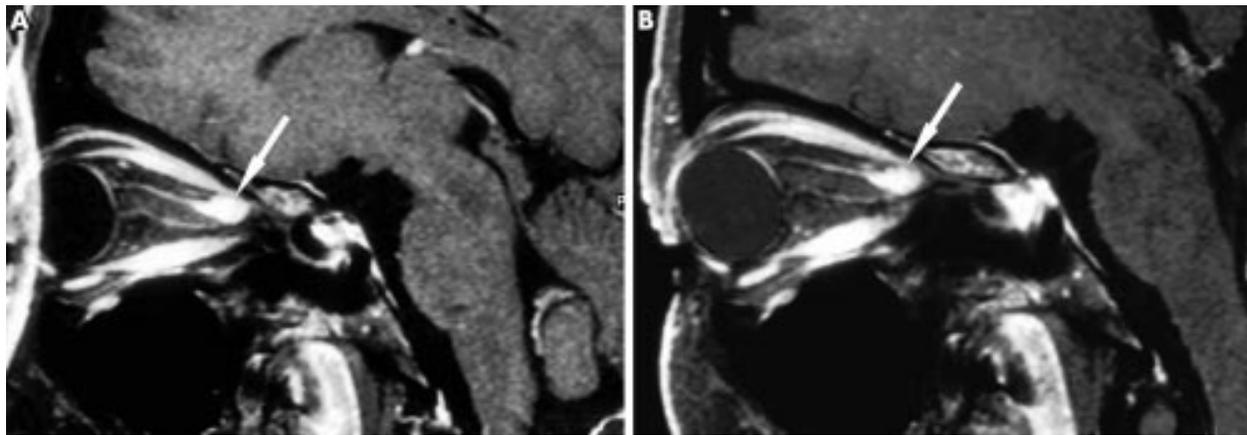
Sagittal T1 weighted magnetic resonance imaging, angulated along the course of the right optic nerve (time of repetition 500 ms, time of echo 16 ms, slice thickness 4 mm), following Gd-DTPA administration. It shows a homogeneously enhancing, 5 × 10 mm fusiform tumour, originating from the upper part of the right optic nerve sheath and compressing the nerve below.
